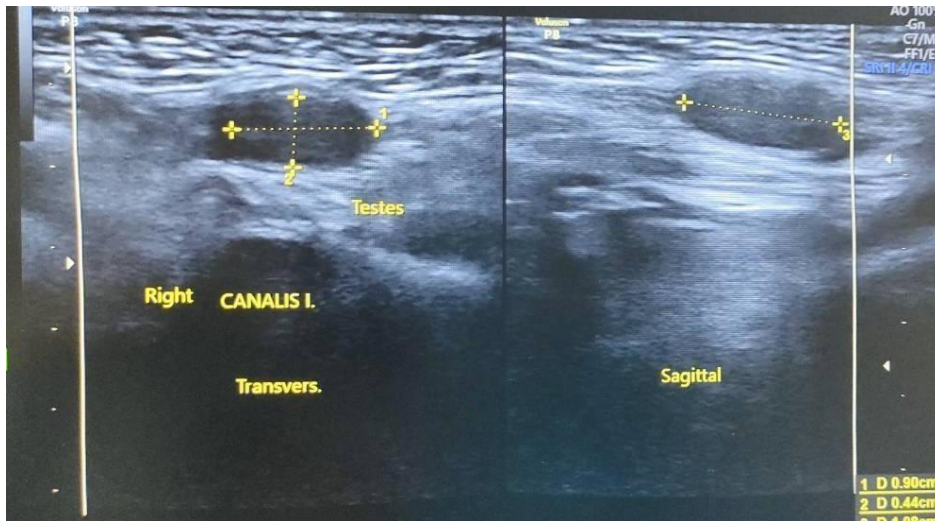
Ultrasound examination of right testicle
